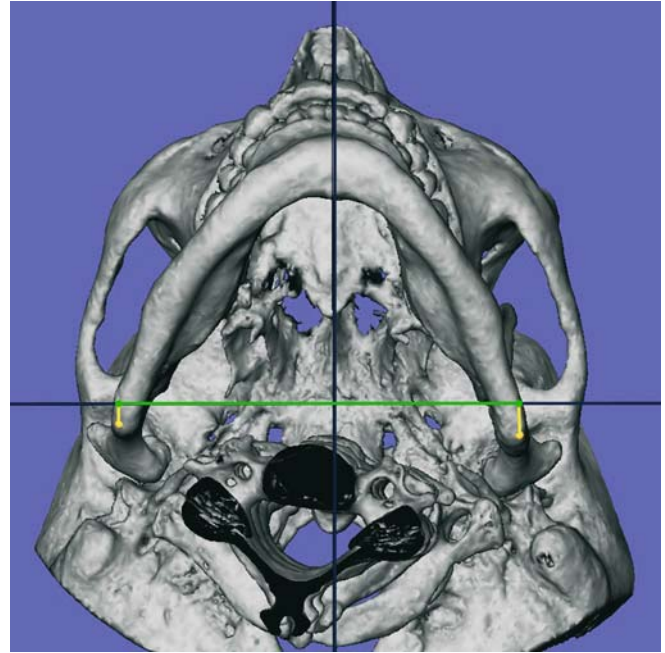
Bigonial width, Go_r-Go_l (3-D CT, hard tissues, patient K.C.)
